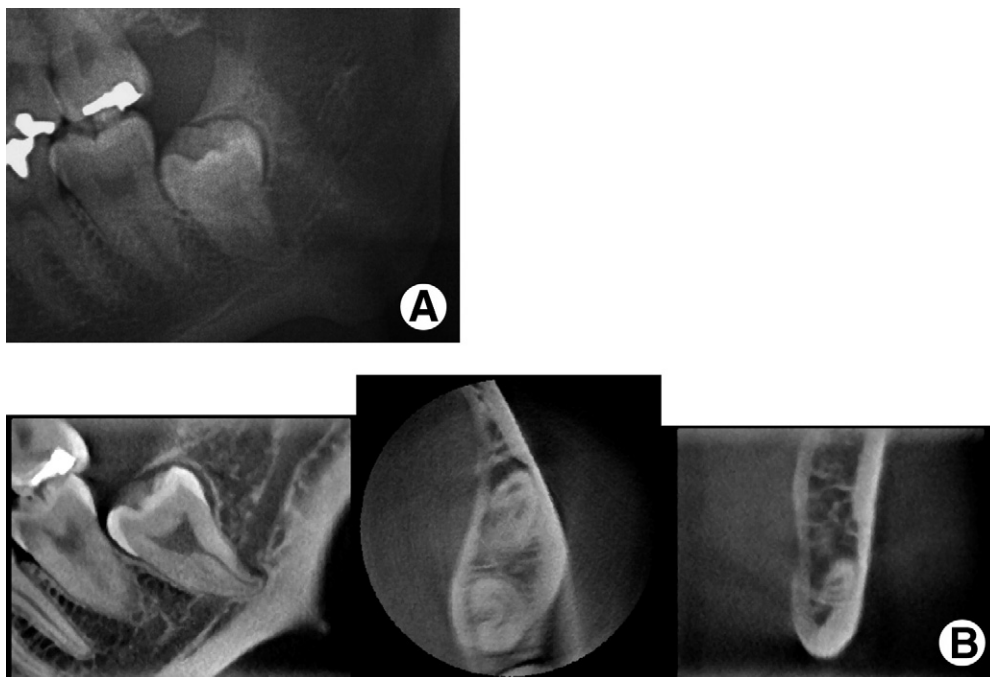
A, Preoperative panoramic radiograph. B, Preoperative dental CT scan.
